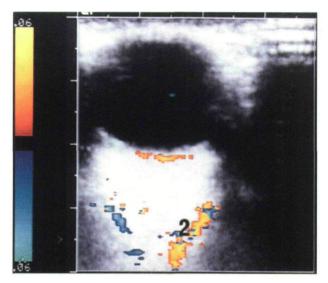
(Top left) Color Doppler ultrasound scan of the orbit showing the position of vessel 1, presumed to be the ophthalmic artery. The scan has been performed in the transverse axis. (Top right) Color Doppler ultrasound scan in the transverse axis showing the position of vessel 2 running along the medial orbital wall. (Left) Color Doppler ultrasound scan of vessel 3 just posterior to the choroid. These vessels lie adjacent to the optic nerve head and are likely to represent a combination of the central retinal artery and posterior ciliary vessels.
